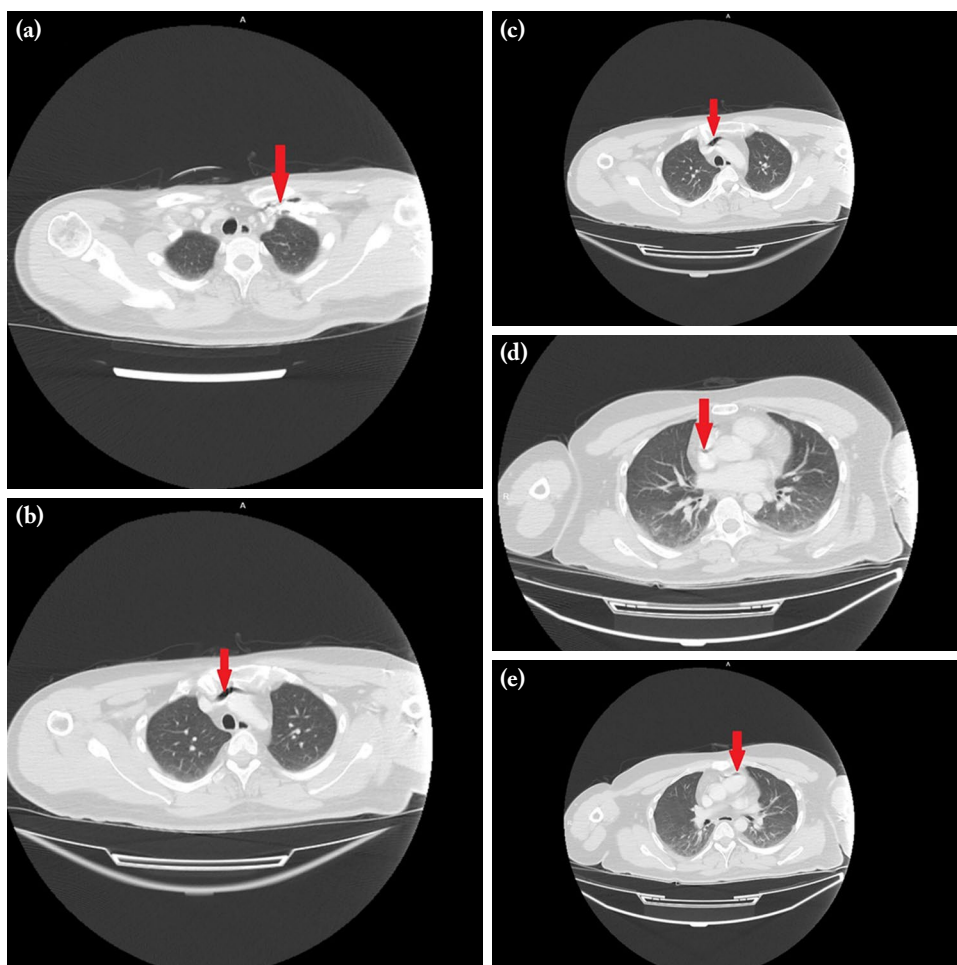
First evaluation computed tomography sections. Air in the (a) left subclavian vein, (b) left brachiocephalic vein, (c) left brachiocephalic vein, (d) vena cava superior, and (e) right ventricle.
